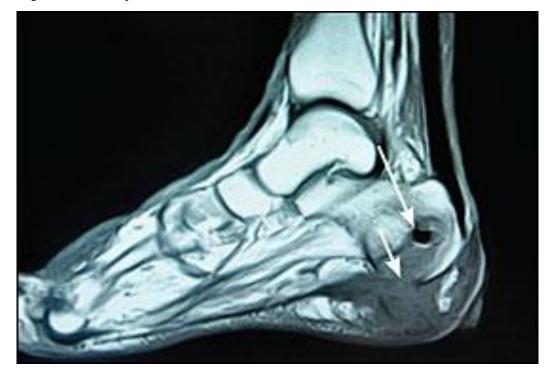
Magnetic resonance image demonstrating abnormal T1-weighted signal within the calcaneus (*long arrow*), consistent with osteomyelitis
